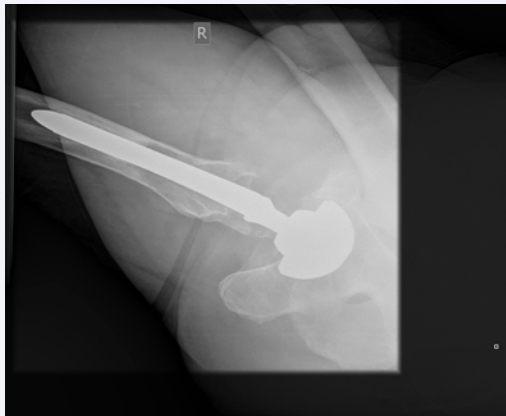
Lateral radiograph demonstrating massive femoral osteolysis.
